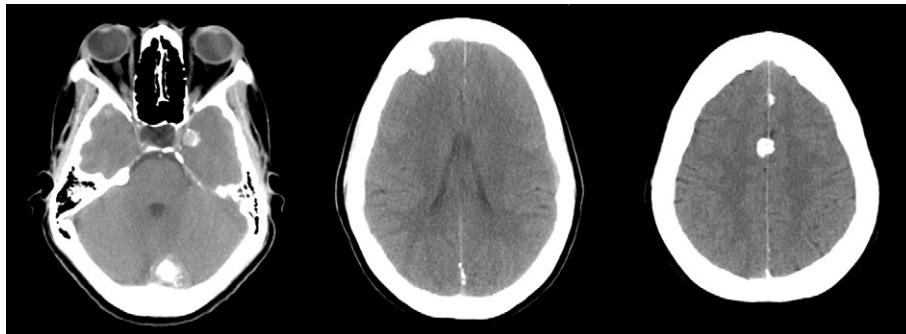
Axial contrast-enhanced CT scan showing multiple meningiomas, most of them totally calcified (falx cerebri, right frontal) or partially calcified (right temporal, left temporal, posterior adjacent to confluence of sinuses).
